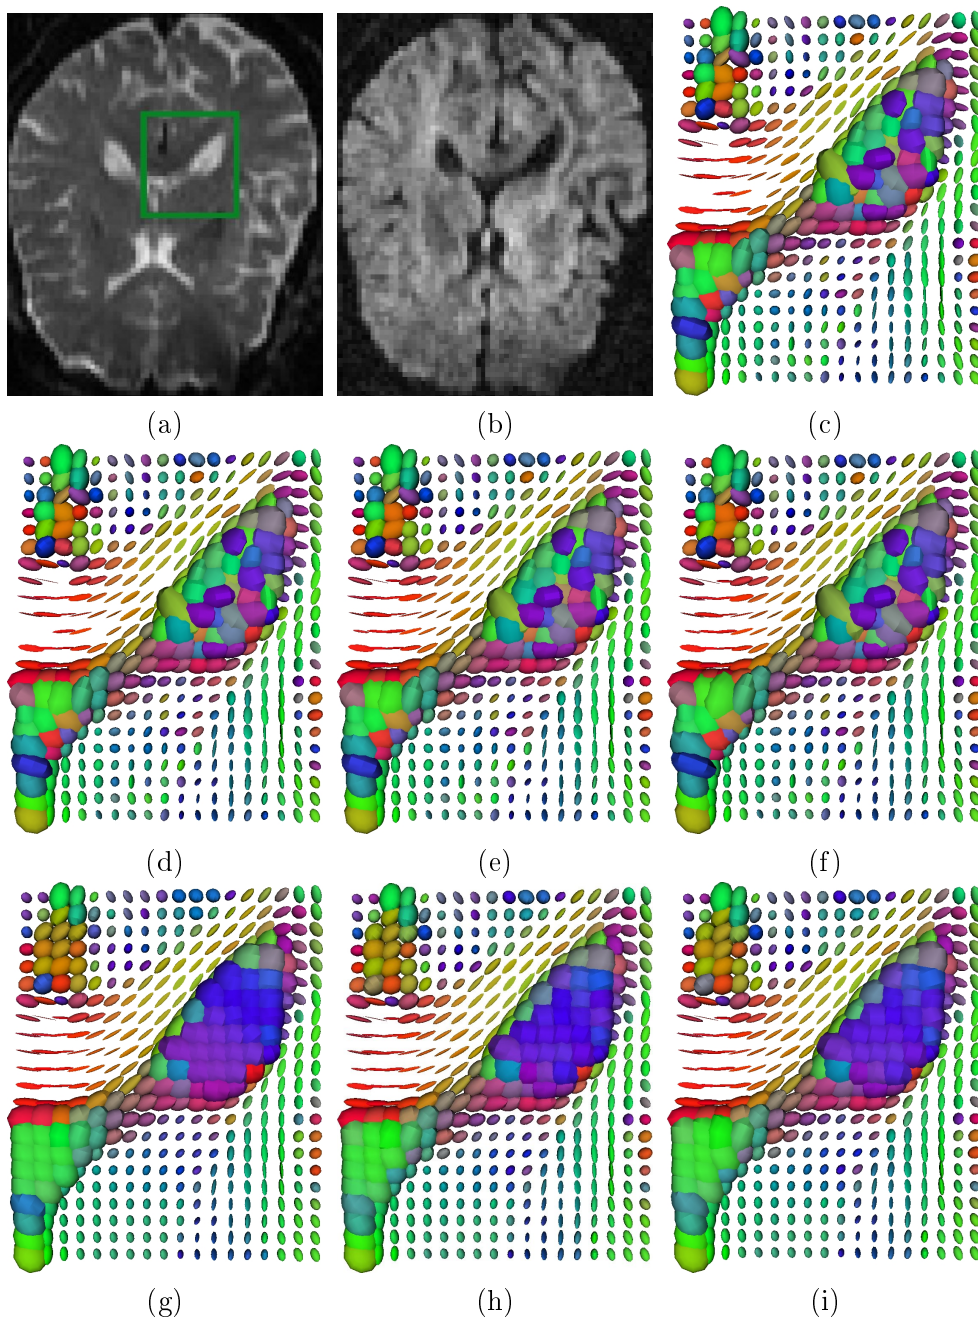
Tensor field estimation of a brain DTI dataset. (a): The b_0 image. The other figures are a closeup on the region delimited by the white square. (b): The DWI corresponding to the encoding gradient $\mathbf{g} = (1, 0, 1)$. (c): Classic estimation. (d): ML log-Gaussian. Some tensors are still missing because their eigenvalues are very close to zero. (e): ML Gaussian. All tensors remain positive definite. (f): ML Rician. All tensors are positive definite and are slightly bigger. (g): MAP log-Gaussian. The regularization term prevents the appearance of non-positive tensors. Note that the boundary between the ventricles and the splenium was preserved. (h): MAP Gaussian and (i): MAP Rician. The three MAP estimators give very close results.
